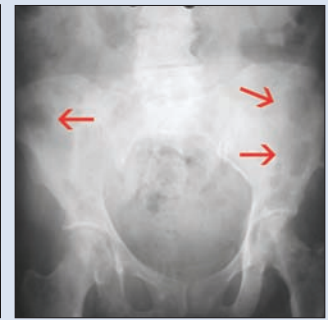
Radiograph of the hip showing bilateral lesions in the iliac crest (arrows).
